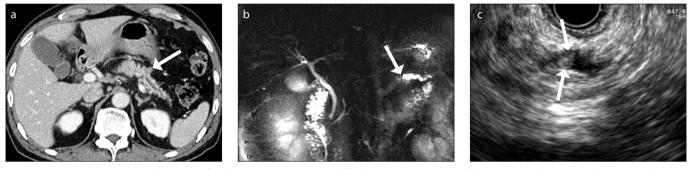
a-c. Case 3, a 65-year-old man with focal pancreatic ITPN with multifocal adenocarcinoma transformation. Axial contrast-enhanced portal phase CT image (a) shows a low attenuating nodular lesion (*arrow*) in the pancreas body with moderately dilated distal pancreatic duct. Two-dimensional MRCP image (b) shows abrupt cutoff (*arrow*) of the dilated main pancreatic duct in the pancreas body. EUS (c) reveals an intraductal tumor (*arrows*) within the dilated main pancreatic duct. The presumptive radiologic diagnosis was pancreatic ductal adenocarcinoma.
